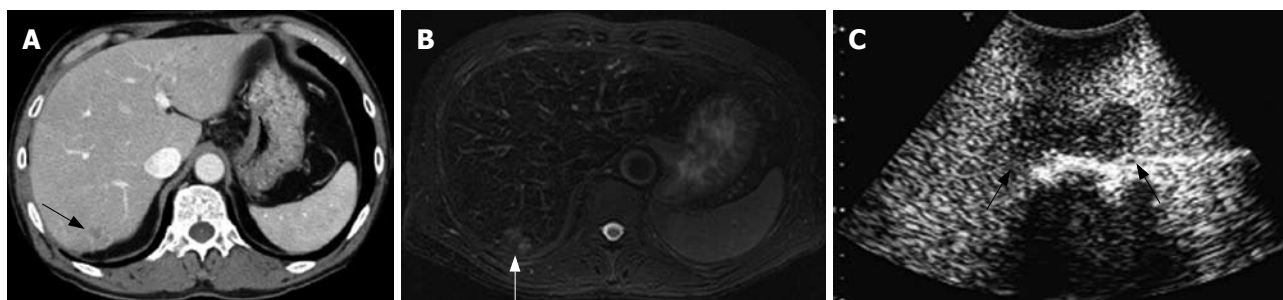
Preoperative CT and SPIO-MRI, and CE-IIOUS. A: An enhanced-CT view and an ill-defined low density mass was detected at the segment 7 (arrow); B: A SPIO MRI view and an ill-defined high intensity mass was detected at the segment 8 (arrow); C: CE-IIOUS view at the delayed Kupffer phase and a well-demarcated hypoechoic mass was detected by CE-IIOUS.
